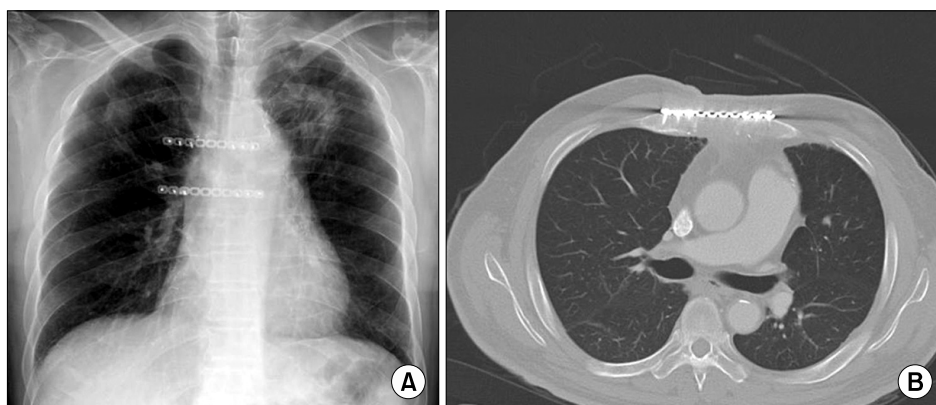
Last follow-up simple chest radiography (A) and computed tomography findings (B) at 6 months following titanium plate fixation. Chest wall integrity was well maintained without any signs of infection.
